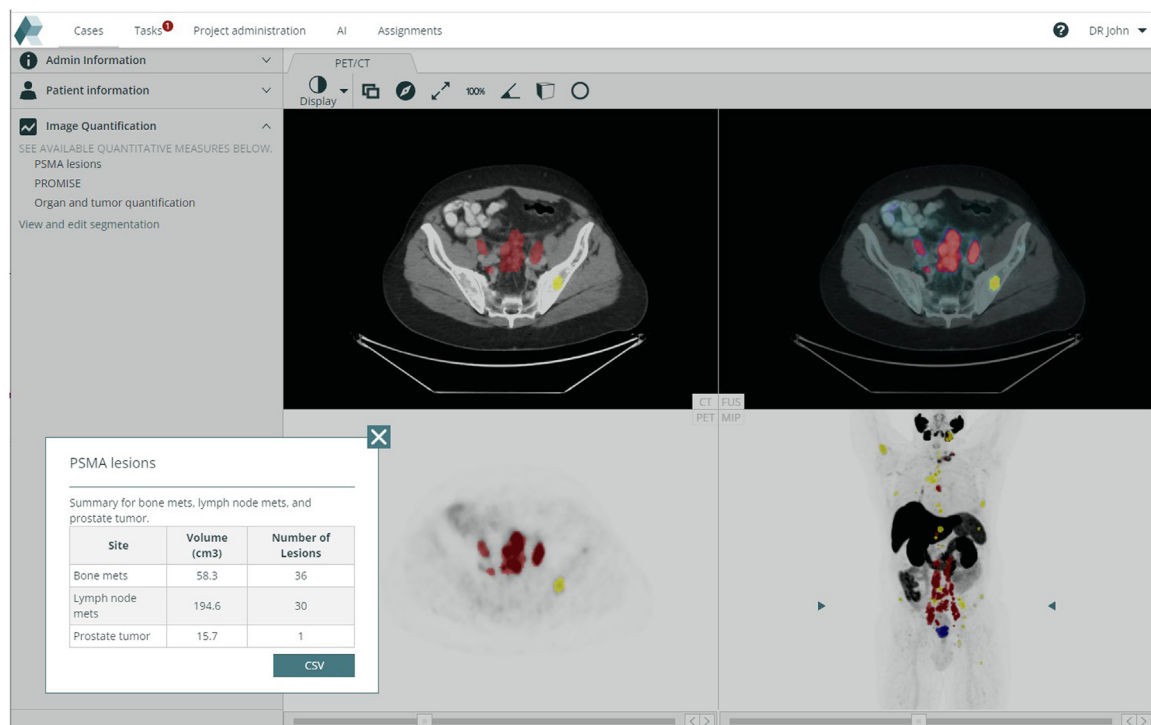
aPROMISE is the only CE-marked and FDA-cleared AI tool for analysis of PSMA PET/CT. It is based on a machine-learning model to detect high local intensity regions of interest (pink) in the PET series. The hotspots selected by the user are automatically quantified as shown in the table to the left.
